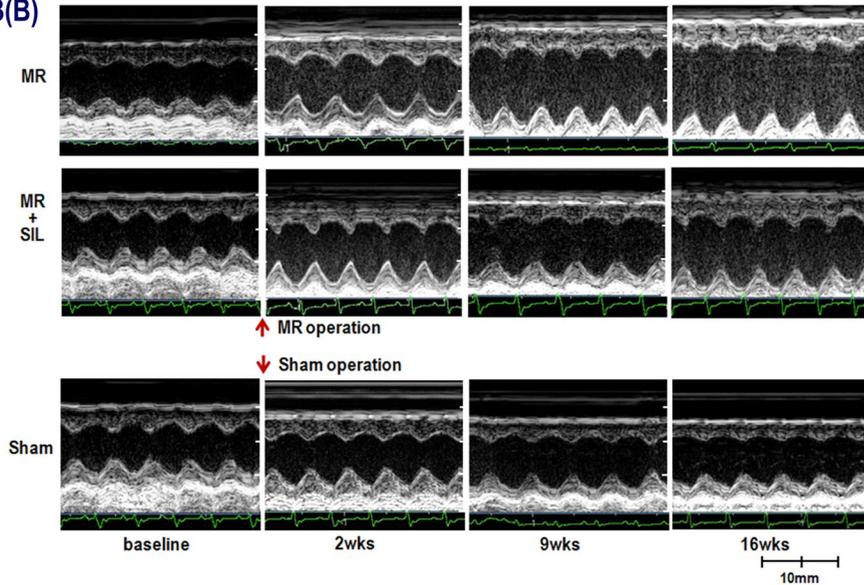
(A) Serial changes in echocardiographic measurements. (B)
